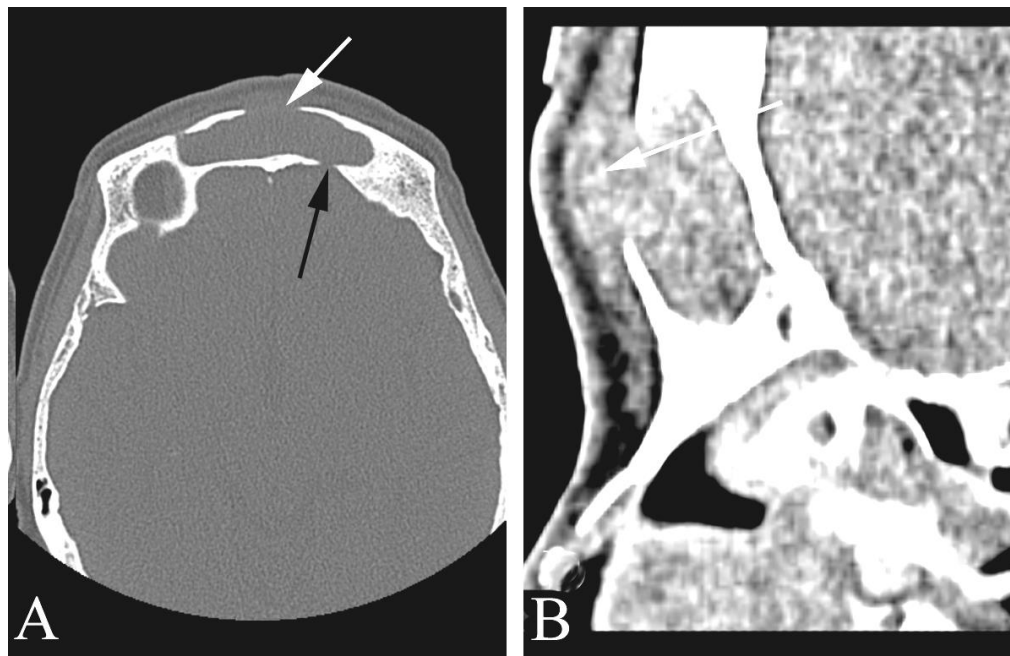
Sinusitis with extension of disease outside of the sinuses in a 77 year old with nasal drainage, headache, and a swollen forehead. A. Axial unenhanced head CT (bone windows) shows complete opacification of the frontal sinus as well as destruction of the anterior wall (white arrow) and posterior wall (black arrow) of the sinus. B. Sagittal reformatted CT image (soft tissue window) shows destruction of the anterior wall of the sinus with soft tissue extending anterior to the frontal bone (arrow) accounting for the patient's swollen forehead. This lesion is also known as "Pott's puffy tumor".
